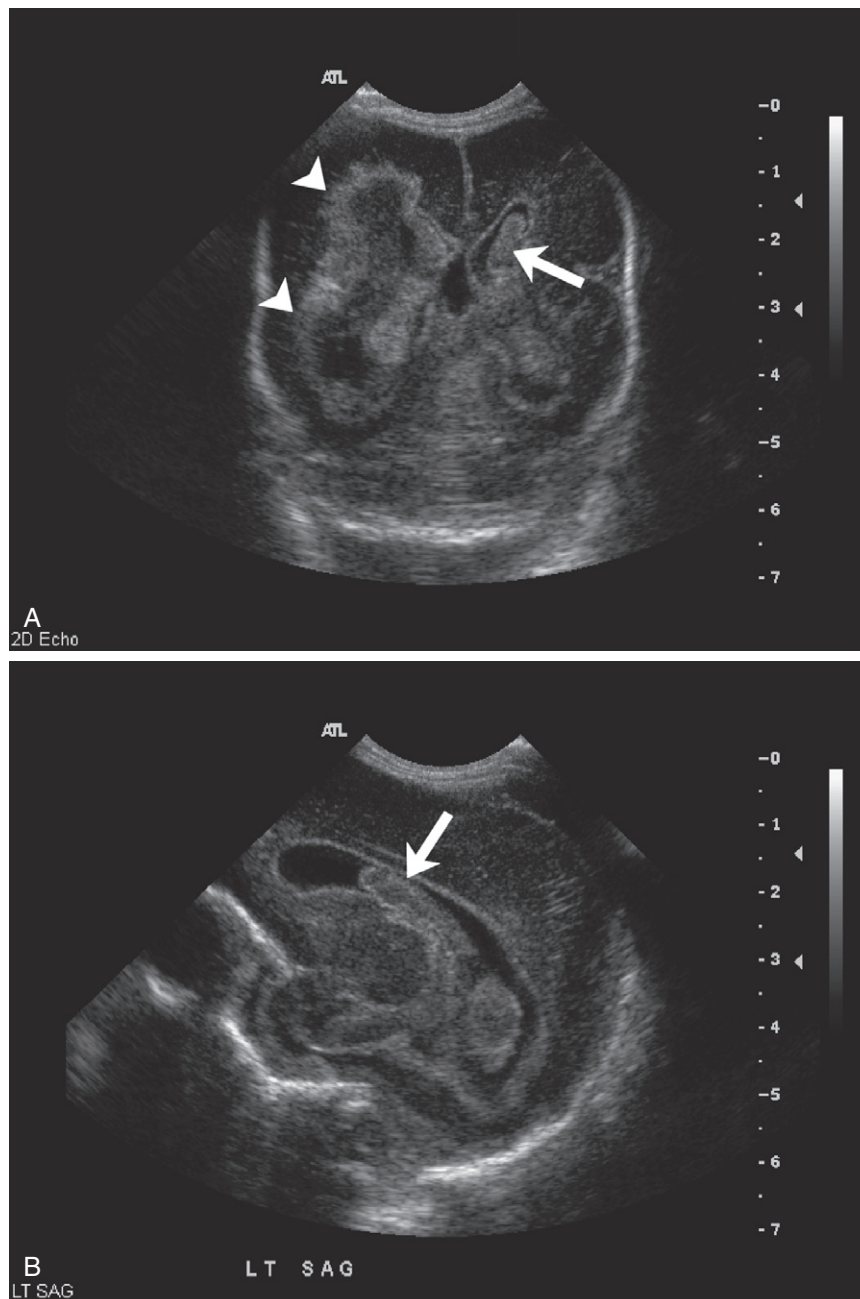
Germinal matrix hemorrhage in a premature infant. Coronal (A) and left parasagittal (B) ultrasound images through the anterior fontanelle demonstrate dilated lateral ventricles with intraventricular extension of clot on the left (arrows) and parenchymal extension on the right (arrowheads) consistent with a grade 3 bleed on the left and grade 4 bleed on the right (some radiologists would assign this hemorrhage an overall grade of 4).
